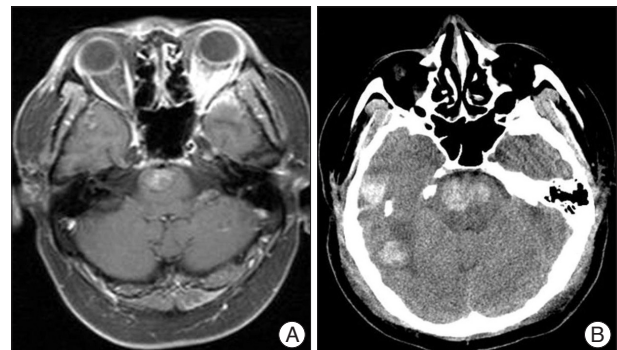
Axial enhanced T1-weighted MR image demonstrating metastatic deposits with hemorrhage involving the pons (A). CT image revealing aggravation of hemorrhagic mass lesions in the right temporal lobe and pons with brain stem compression (B).
